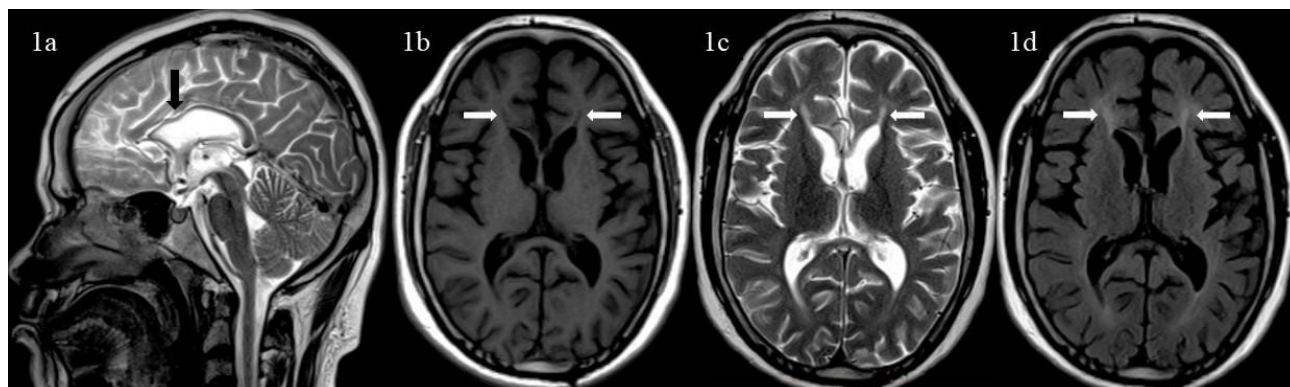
T2 weighted sagittal MRI shows marked thinning of the corpus callosum (1a). T1 weighted axial MRI shows the hypointense signal at the tips of the frontal horns of the lateral ventricles having a triangular shape (1b), T2 (1c) and FLAIR (1d) axial MRI image at same level shows corresponding hyperintense signal.
